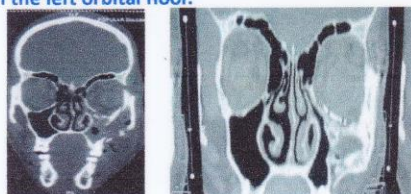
5, 6 Pre and Post operative coronal CT Scan
